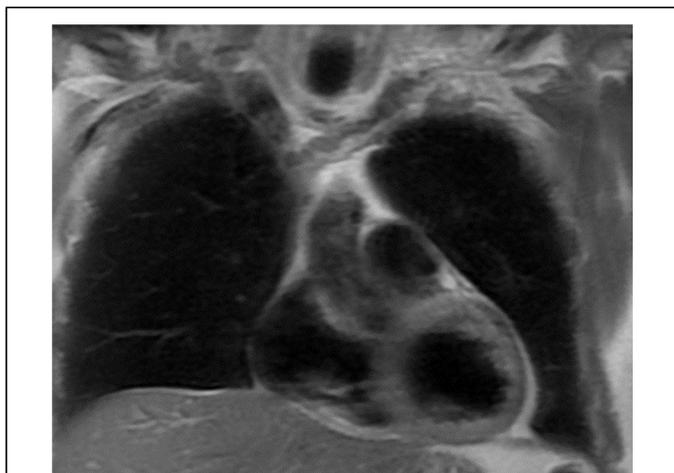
Cardiac magnetic resonance image revealing normal left and right ventricular size and function, left ventricular ejection fraction of 55%, and no evidence of intramyocardial fibrosis/scar, infiltration, inflammation, or hemodynamically significant valvular pathology.
